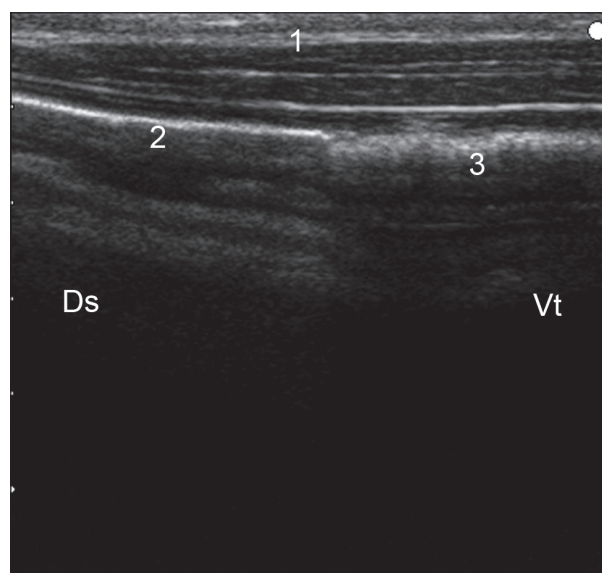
Ultrasonogram of the rumen showing the transition between the dorsal gas cap and ingesta. The wall of the rumen is seen as an echoic line. Reverberation artifacts that run parallel to the ruminal wall are evident near the gas cap, ending abruptly at the transition to the ingesta. A 5.0 MHz linear transducer was used to scan the region of the 11th intercostal space on the right side. 1 Abdominal wall, 2 Ruminal wall in the region of the dorsal gas cap, 3 Ruminal wall in the region of ingesta, Ds Dorsal, Vt Ventral.
